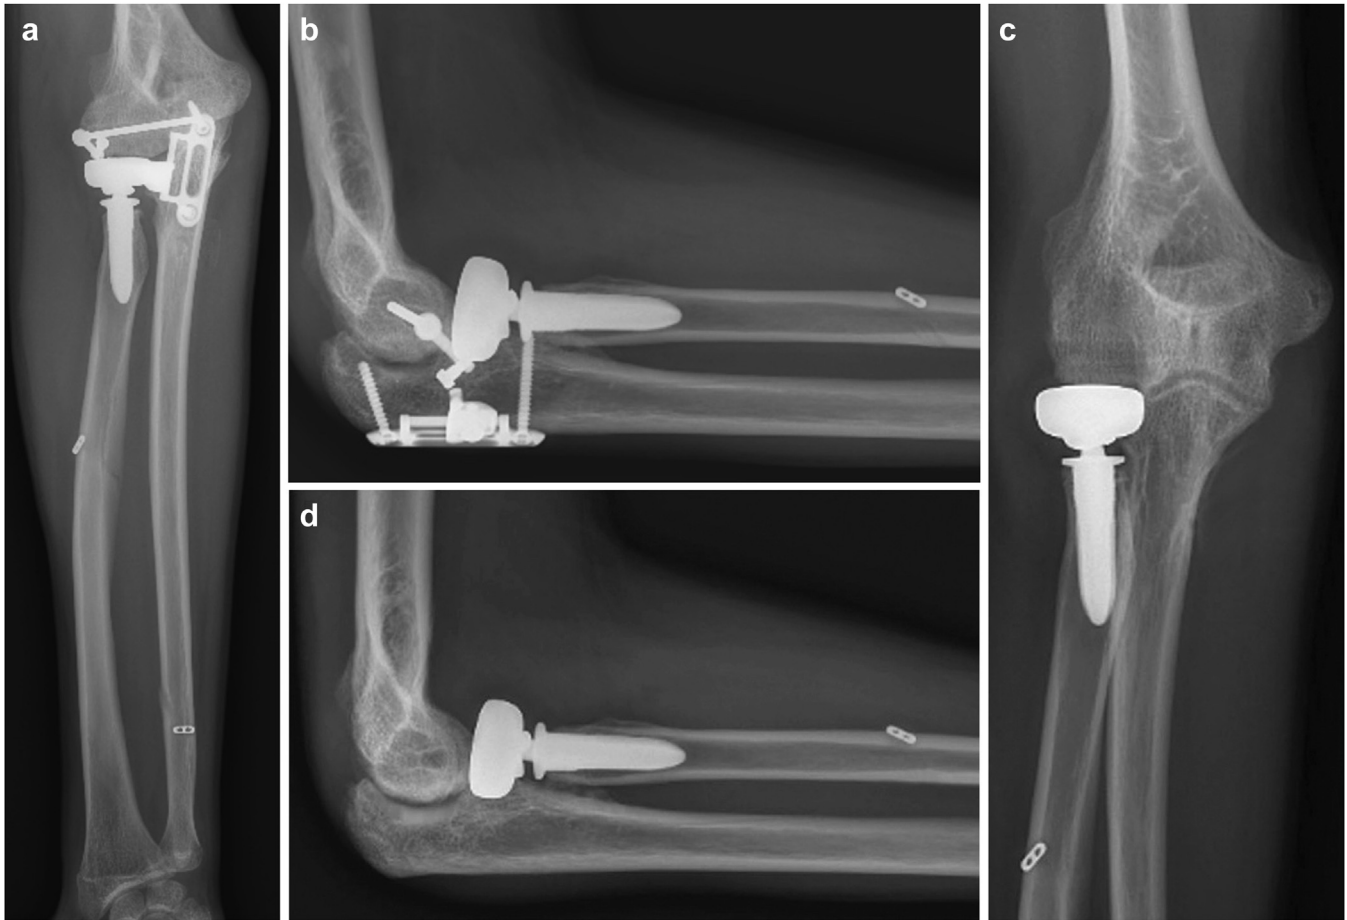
(a and b) Anteroposterior and lateral radiographs at 3 months and (c and d) 5 months postoperatively following removal of the internal joint stabilizer.
